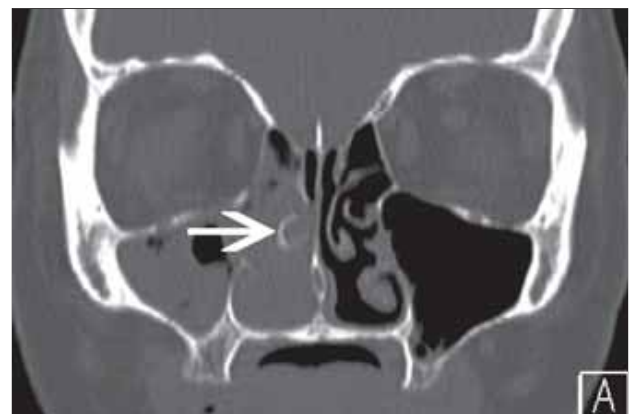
Pre-operative CT scan predicting the site of attachment of an inverted papilloma to the right middle turbinate, displaying intermediate osteitis (arrow).
